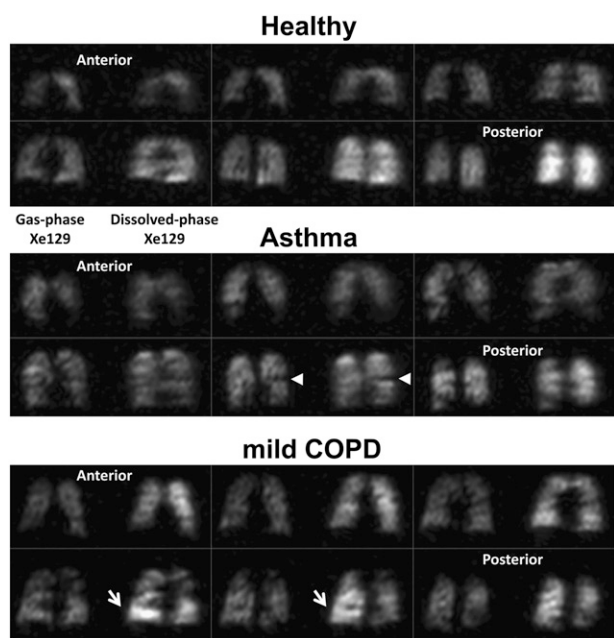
3D coronal acquisitions of the whole lung in subject 8 (healthy), subject 7 (asthma), and subject 10 (mild COPD) show marked spatial variations in ventilation and gas uptake in the subjects with asthma or COPD compared with generally uniform distributions in the healthy subject. Each panel shows the central six 20-mm-thick Xe129 images from the respective acquisition. For the subject with asthma, arrowheads indicate signal dropout at the location of a ventilation defect; a band of elevated signal is seen just below this defect in the dissolved-phase component. For the subject with mild COPD, arrows indicate regions of elevated signal intensity in the dissolved-phase component. MRI pulse-sequence parameters for all acquisitions include repetition time (TR), 50 ms; echo time (TE), 2.8 ms; flip angle at dissolved phase, 20°; bandwidth, 110 Hz/pixel (6.2 ppm/pixel); and spatial resolution, 12 × 12 × 20 mm.
